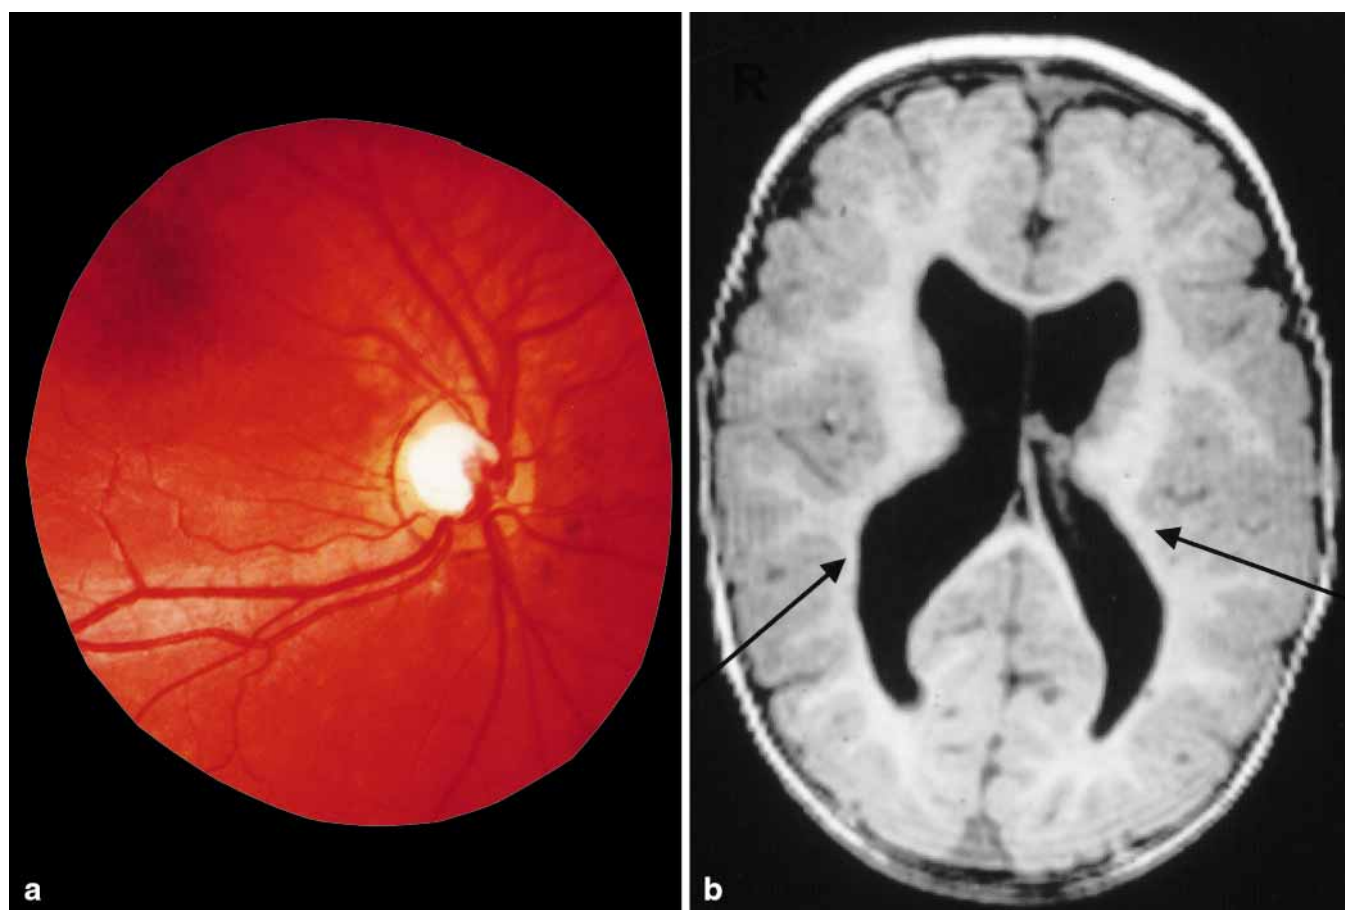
Fundus photograph of the right eye (a) in a 6-year-old boy with periventricular leukomalacia (patient 17, Table 1), demonstrating a large optic cup in a normal sized optic disc. T1-weighted axial image showing bilaterally reduced periventricular white matter (arrow). This and other images from the same study also shows global reduction of the amount of white matter. The ventricles are dilated secondary to this focal as well as general loss of white cerebral matter. These findings are pathognomonic for Periventricular Leukomalacia.
